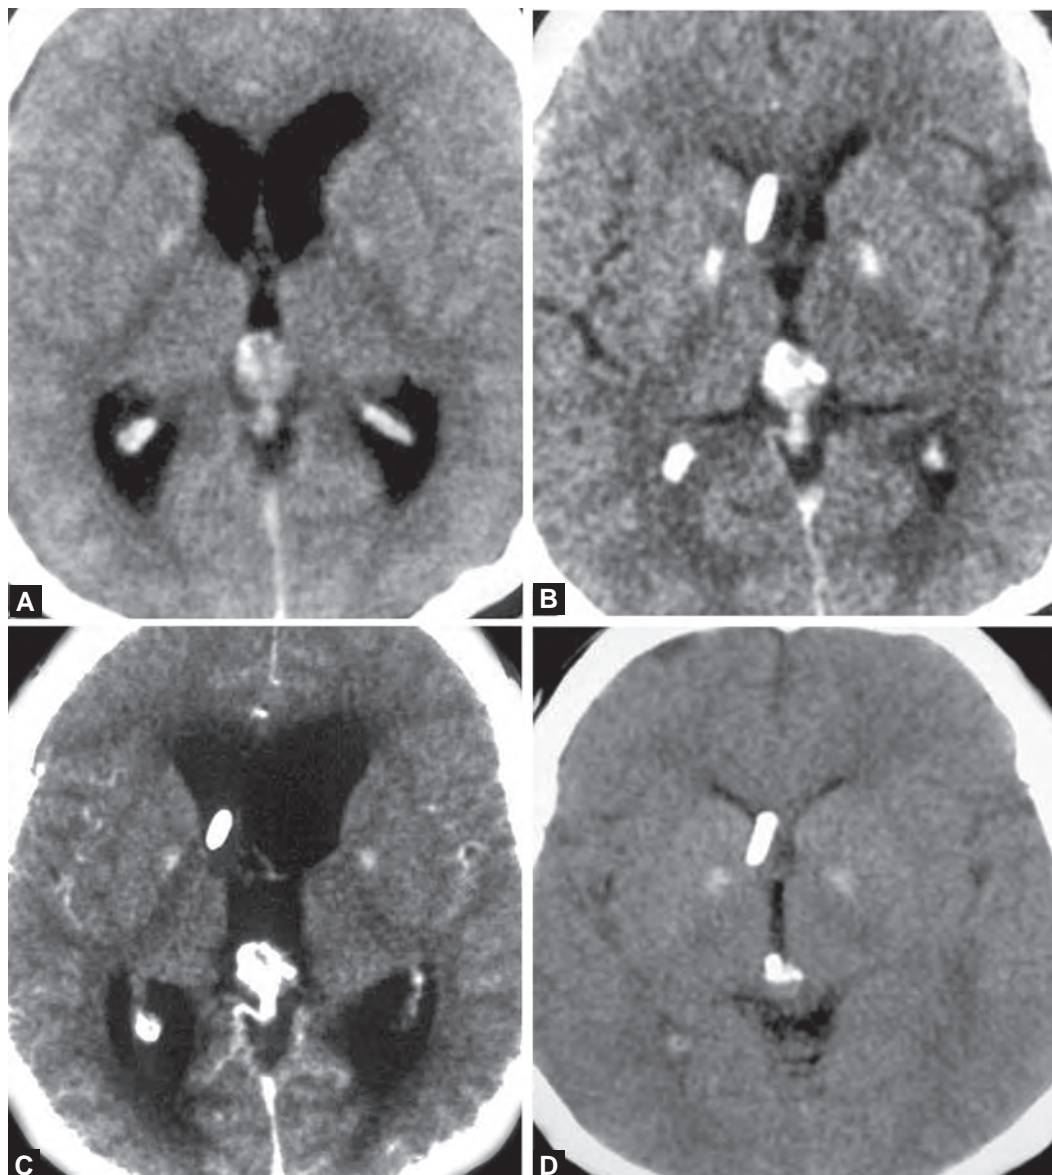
to D: A 20-year-old man presented with headache, papilloedema, ataxia and tremors. (A) The plain CT showed a pineal mass with punctate calcification. (B) MRI showed a T1-isointense tumour and T2-hypointense tumour. (C) There was non-uniform contrast enhancement. Endoscopic third ventriculostomy and biopsy-decompression of the tumour was done. The pathology was pineoblastoma. (D) The immediate post-operative CT, before removing the ventricle drain, showed reduction in size of tumour and no significant haemorrhage. He underwent craniospinal axis irradiation and remained asymptomatic 6 months later
